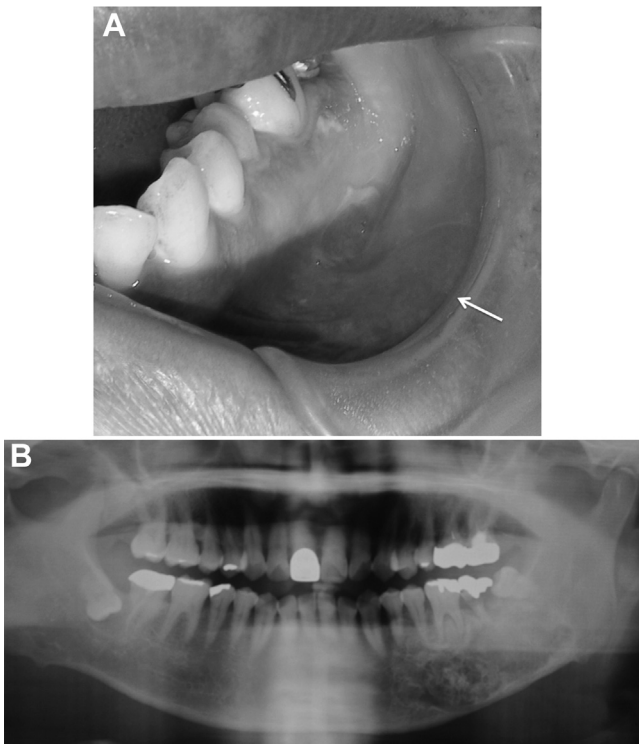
(A) Clinical view of a small painless bony swelling in the oral vestibule of the left mandibular posterior region (arrow). (B) Panoramic radiographs revealed a multilocular lesion with mixed radiolucent–radiopaque content.
